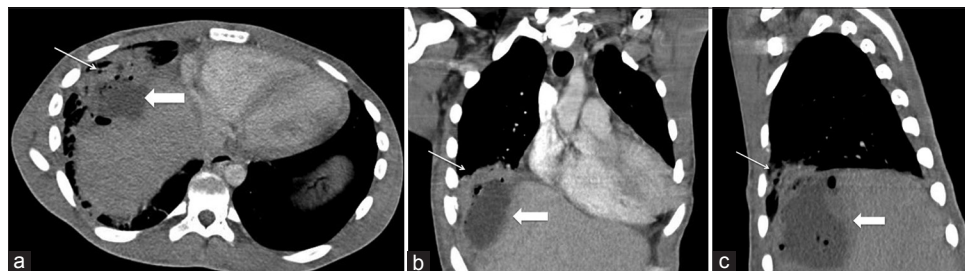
Axial (a), coronal (b) and sagittal (c) images of a computed tomography (CT) of the chest obtained upon the patient's second hospital admission demonstrates development of a hepatic dome fluid collection (thick arrow) associated with air foci and a right middle lobe consolidation (thin arrow). At the time of this CT, no biliptysis had been reported
